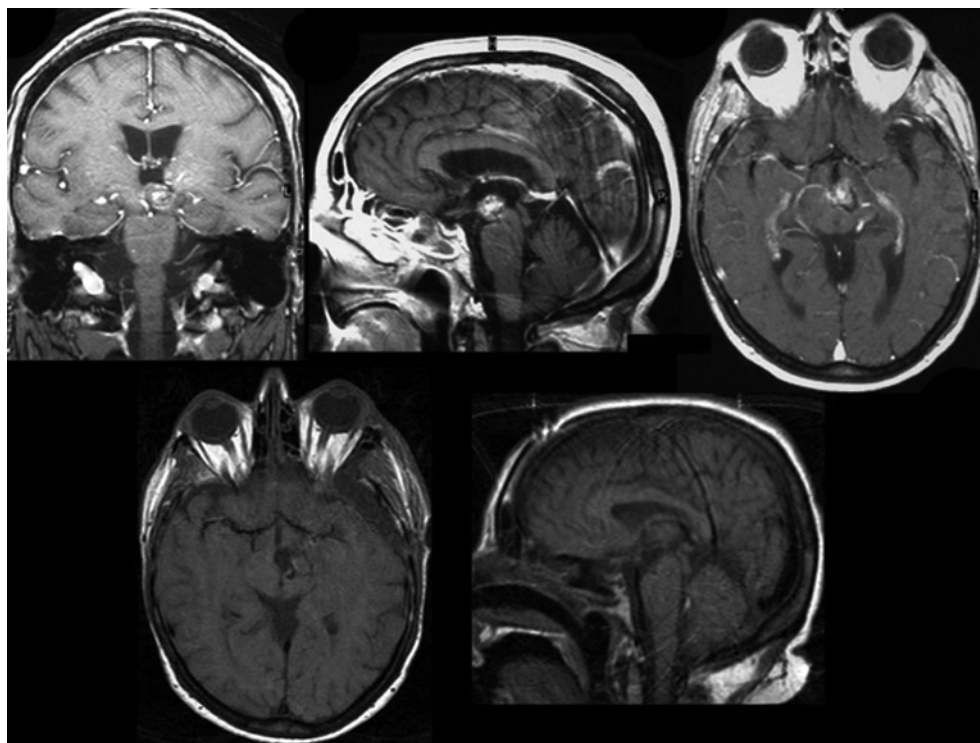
Orbitozygomatic approach. Preoperative (top) and postoperative (bottom) MRI of a cavernous malformation of the rostral and ventral brainstem approached by an orbitozygomatic approach.
